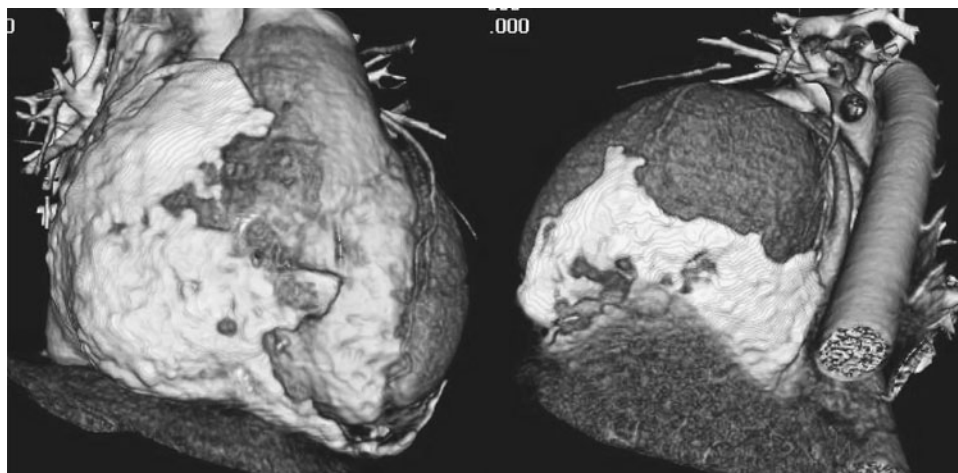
Preoperative evaluation of chronic calcific pericardial thickening prior to pericardial stripping. Three-dimensional volume-rendered images from cardiac CT demonstrate extensive regional pericardial calcification (*white areas*). This includes over the right ventricular outflow tract, right ventricle, right atrium, and entire inferior wall extending inferolaterally. Anterior and anterolateral pericardium was normal.
